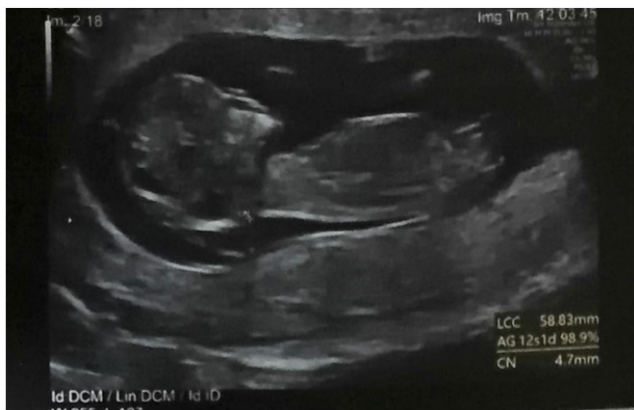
Ultrasonographic Appearance of Cervical Cystic Hygroma with 4.5 mm Nuchal Thickness
